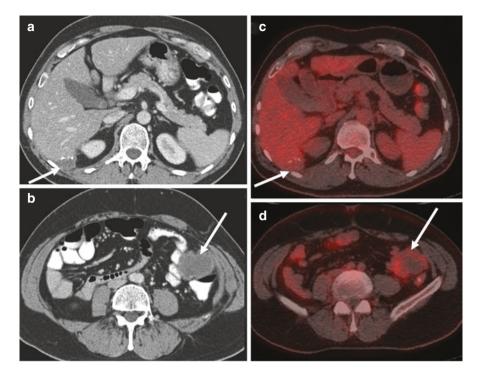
Peritoneal metastases from a mucinous primary. 67-year-old male presented with a primary mucinous type adenocarcinoma of the sigmoid colon and developed peritoneal metastases. Axial contrast enhanced CT images (a and b) demonstrate low attenuation deposits in the left subhepatic space (arrow in a) and left paracolic gutter (arrow in b). FDG PET-CT images (c and d) do not show any abnormal increased uptake corresponding to these deposits. This is due to the low cellularity of the mucinous metastases and FDG PET-CT can be false negative in such cases which need careful assessment of the CT component for accurate assessment of the disease extent
